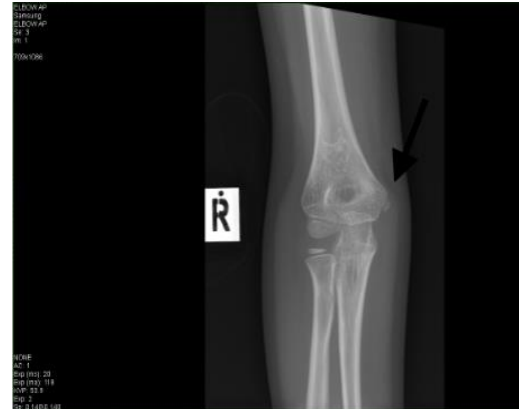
The radiograph of the right elbow lateral view showed the presence of an ossification centre at the medial epicondyle
